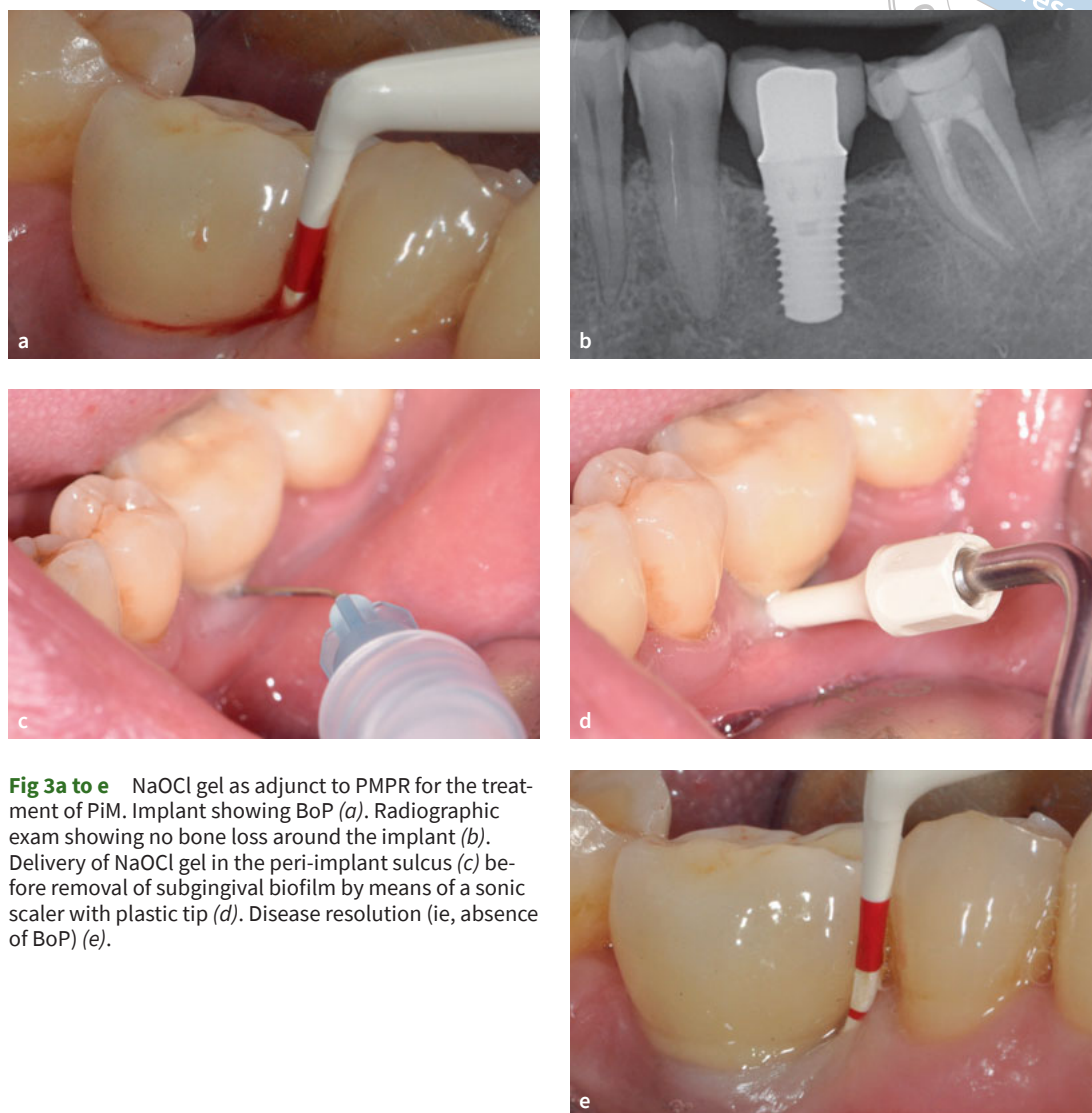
to e NaOCl gel as adjunct to PMPR for the treatment of PiM. Implant showing BoP (a). Radiographic exam showing no bone loss around the implant (b). Delivery of NaOCl gel in the peri-implant sulcus (c) before removal of subgingival biofilm by means of a sonic scaler with plastic tip (d). Disease resolution (ie, absence of BoP) (e).
